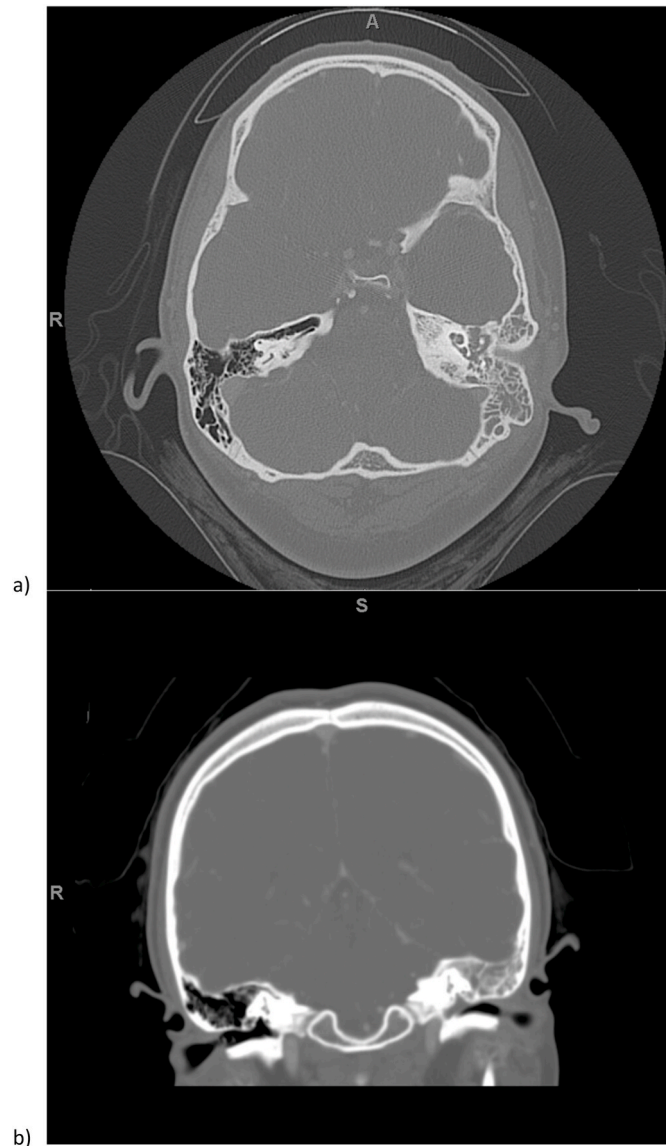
Axial (a) and coronal (b) cuts of computed tomography showing left non-coalescent mastoiditis in a 13-year-old female with complete facial paralysis secondary to acute otitis media.
